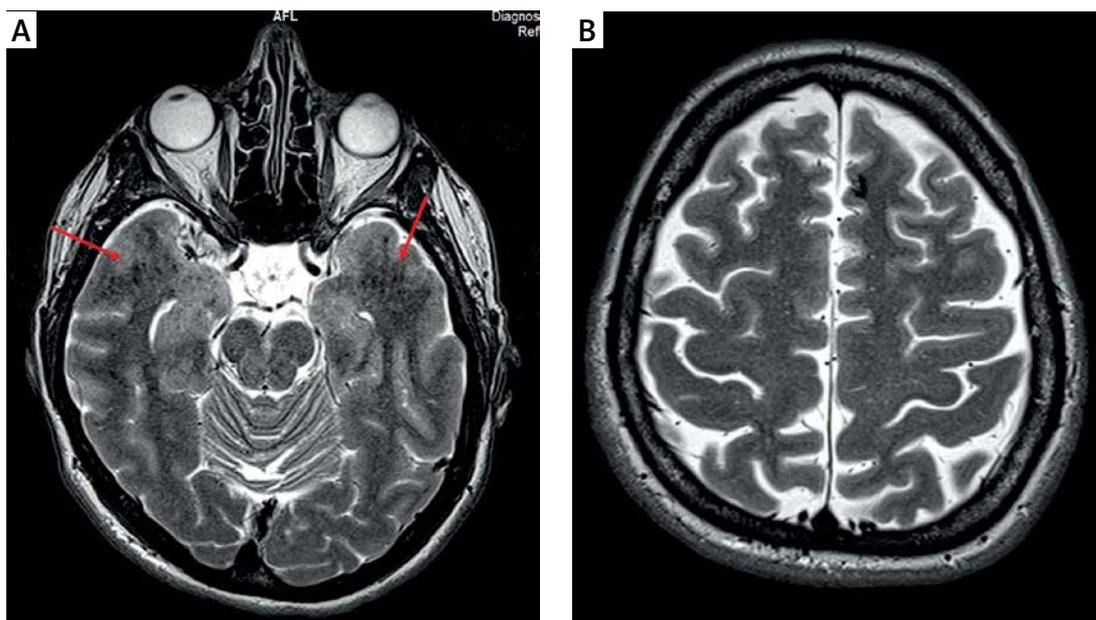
MRI T2-weighted images showing hypointensities in the temporal poles bilaterally, the midbrain, and the frontal lobe on the left side being interpreted as cavernomas
